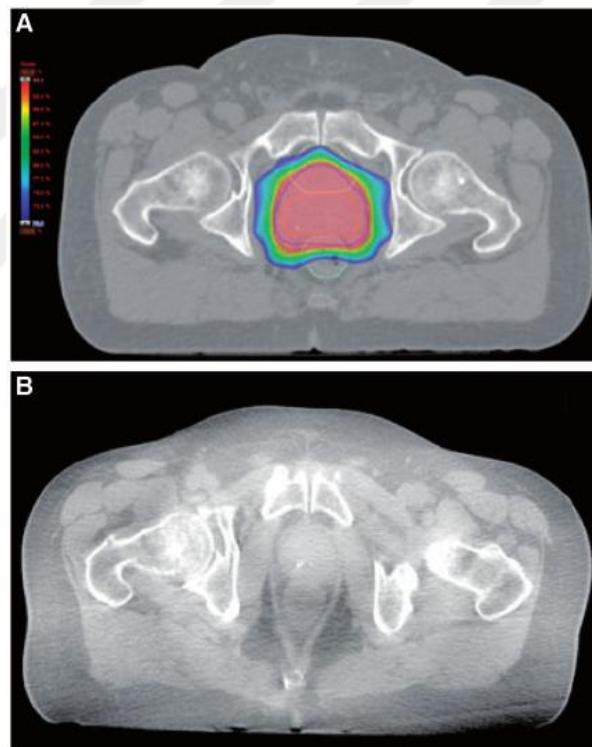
Radiotherapy treatment plan applied to a prostate cancer patient with an appropriate dose and post-radiotherapy with Cone Beam Computed Tomography (CBCT) method (Høyer, M. et al., 2011).
